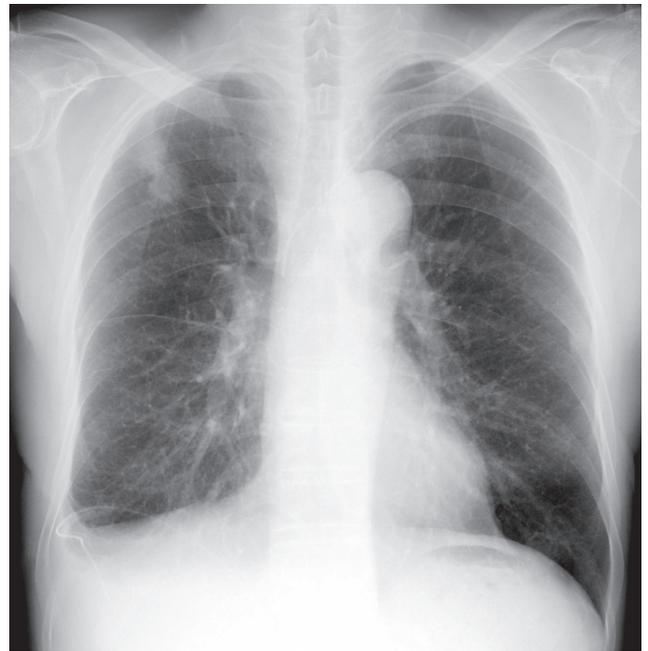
Chest radiograph, 2 months after placement of the shunt, showing a marked improvement of chylothorax and chylopericardium.
